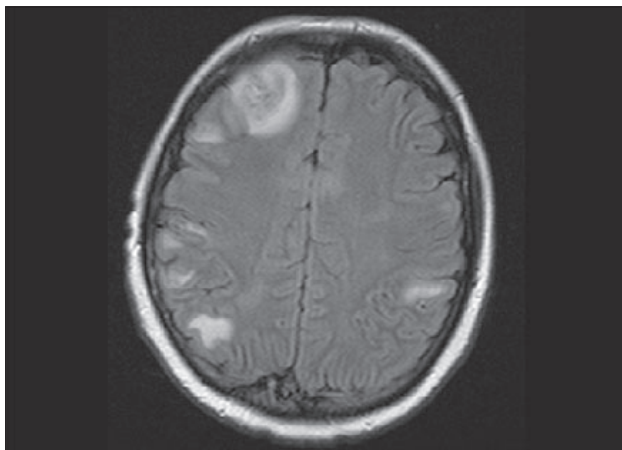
MRI of brain showing CNS leukemic infiltrations.
